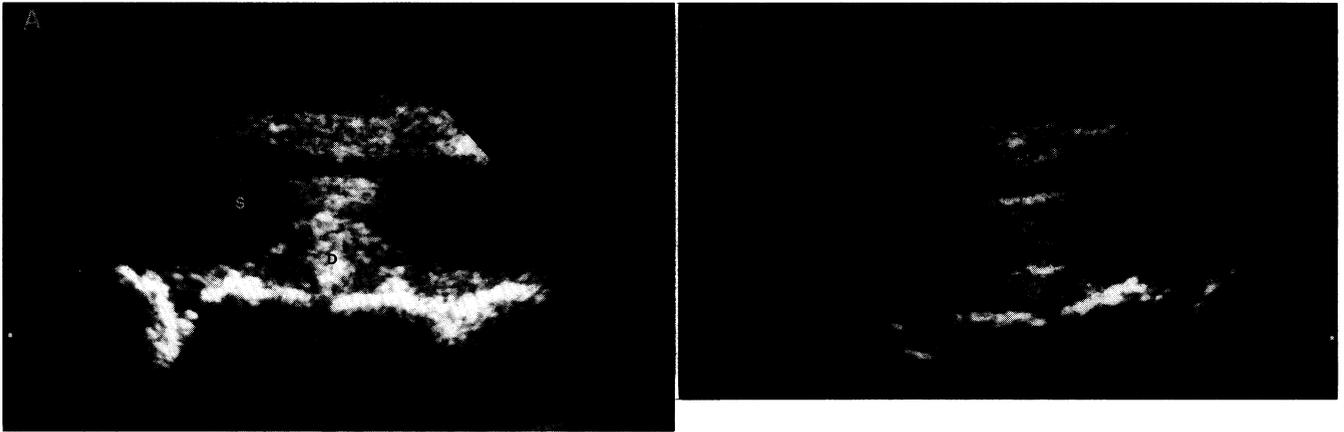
(A) Longitudinal sonogram of a disk herniation (D) impinging on the spinal cord (S). (B) After removal of disk tissue, the cord compression is improved.
